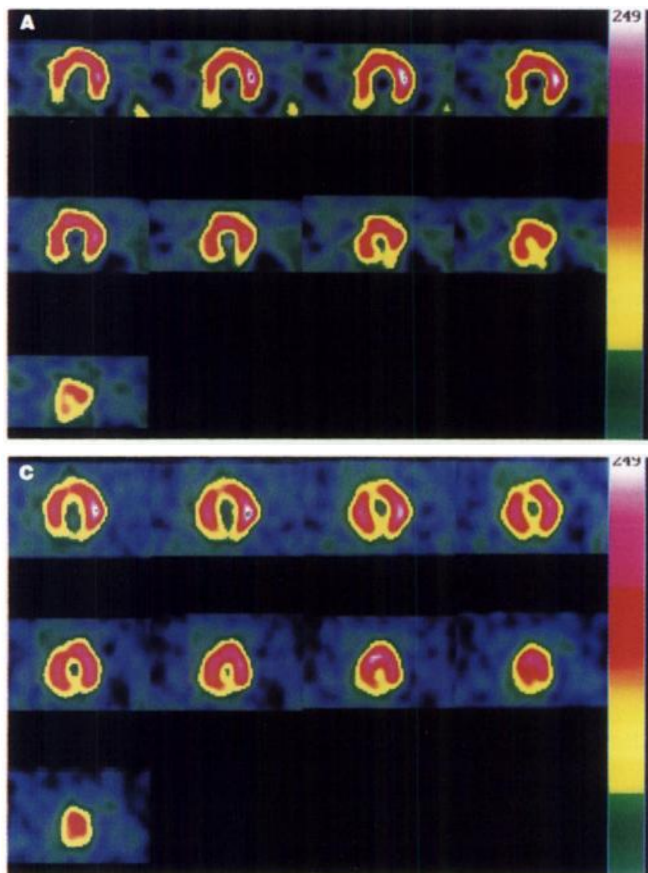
A 36-yr-old man with chronic ischemic cardiomyopathy. (A) Twenty-four hour ^{201}Tl and (B) ^{18}F FDG-PET attenuated short-axis images of the heart show an inferior wall defect. (C) ^{18}F FDG-SPECT nonattenuated short-axis images of the heart show a similar defect. The slight decrease in activity seen in the superior medial aspect of the image is overemphasized by the color scale. This was verified on review of the gray scale images.
